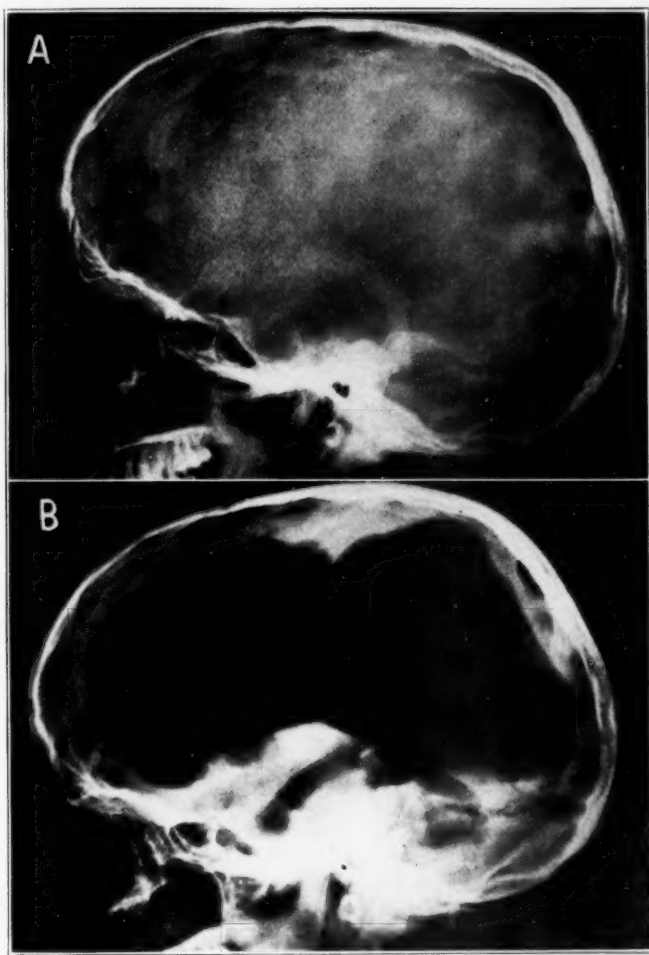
A*, lateral roentgenogram of the skull, showing convolutional markings and the dilated sella turcica. *B*, lateral ventriculogram showing the marked hydrocephalus and the dilatation of the fourth ventricle.
